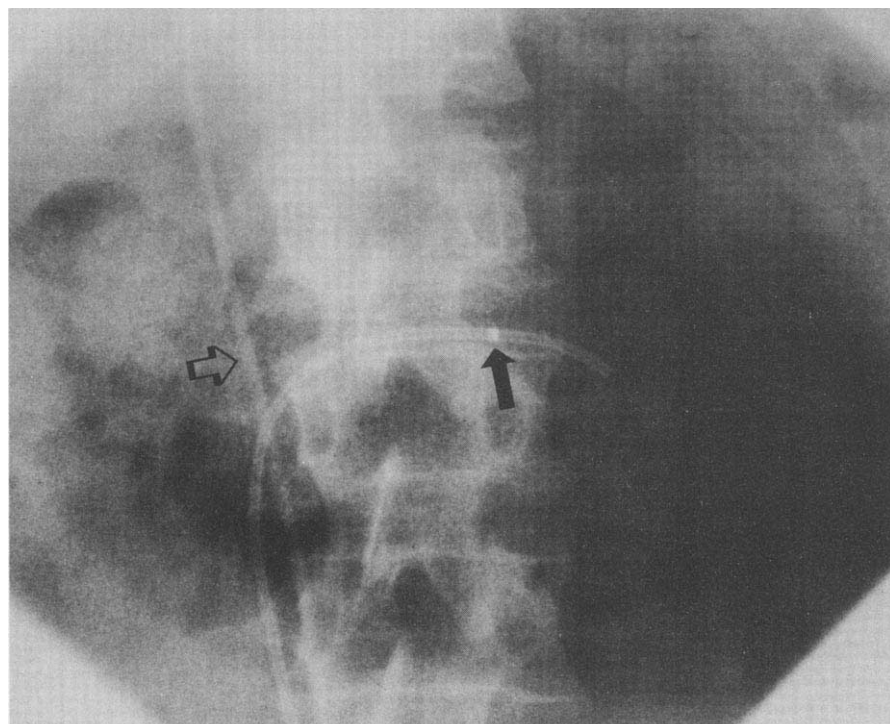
Radiograph showing thermodilution catheter in the left renal vein (solid arrow). A Swan-Ganz catheter is seen in the inferior vena cava (open arrow). Note that the thermistor (tip of solid arrow) lies well within the renal vein.
